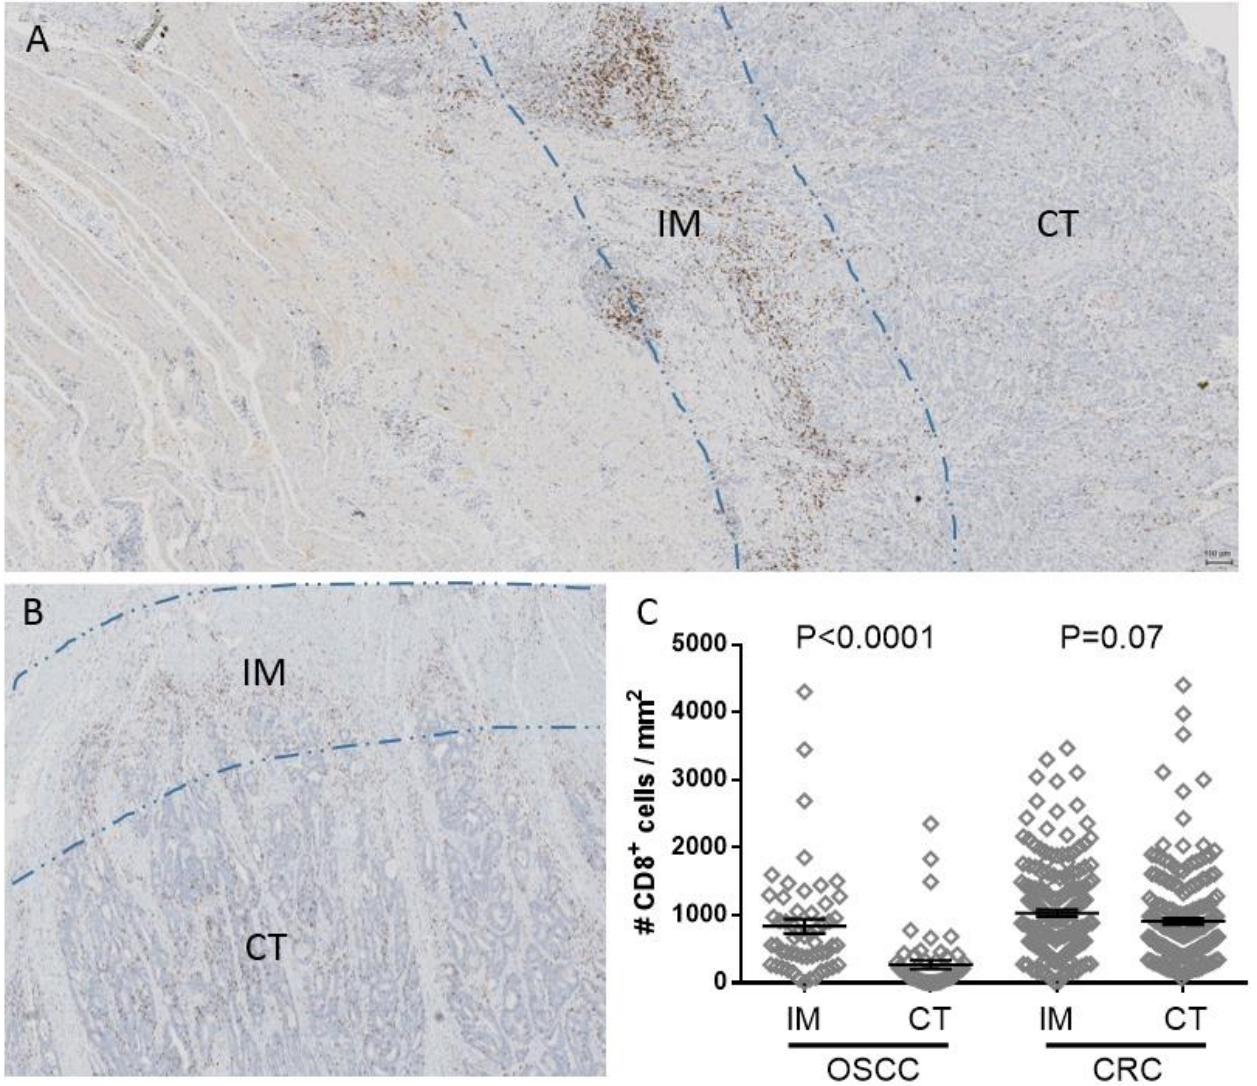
Difference in the location of immune infiltrate between OSCC and colorectal cancer. A) Representative example of CD8 infiltrate for OSCC B) Representative example of CD8 infiltrate for colorectal cancer C) Enumeration of immune infiltrates using Definiens platform. IM: Invasive Margin, CT: Center of Tumor
